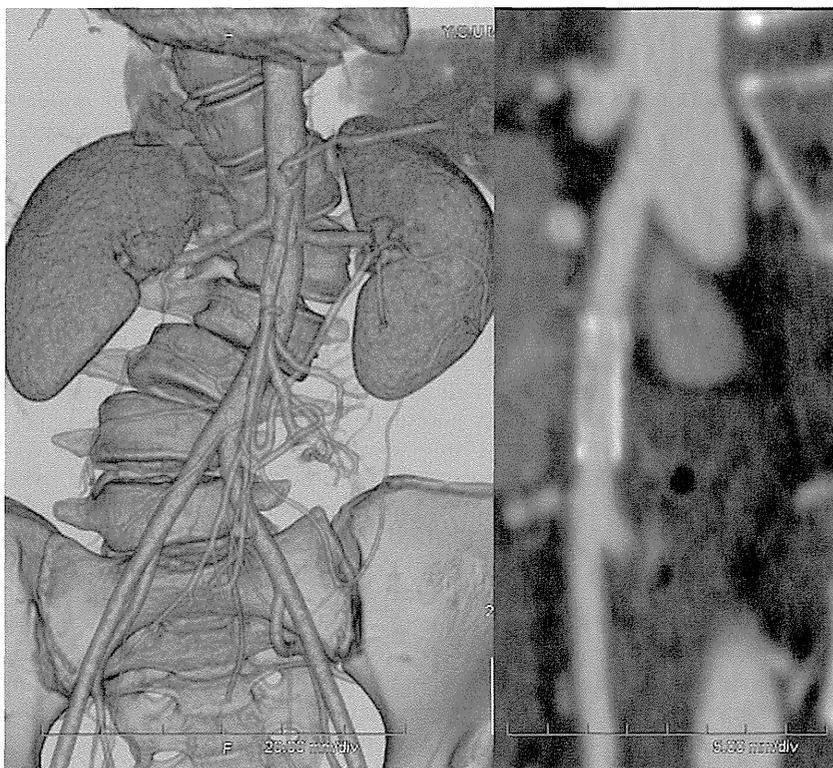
CT scan obtained 2 years after surgery, showing that the stent remains well patent.
